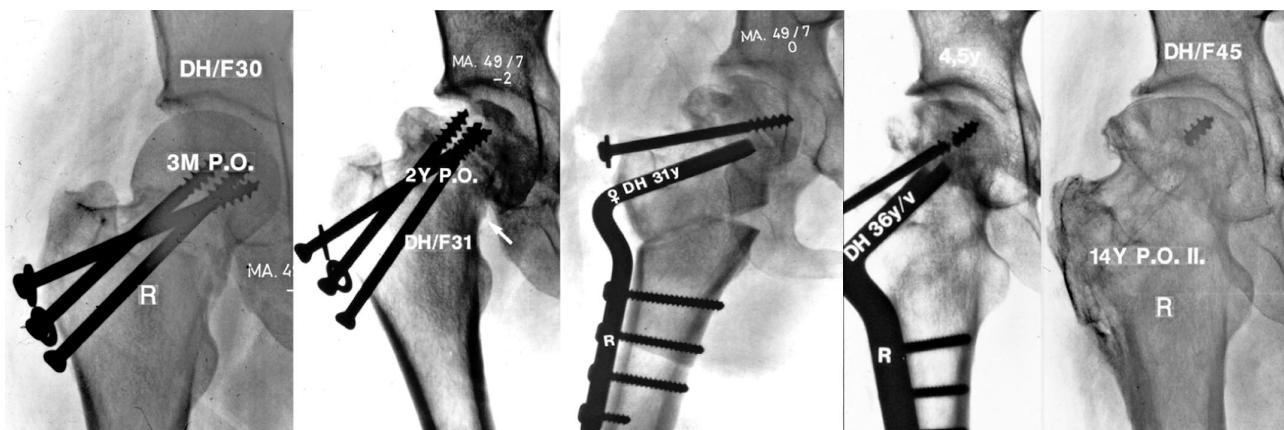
a: Female, 30 years. Three months after screw fixation of a displaced femoral neck fracture. Healed fracture. The patient refused further controls. b: Two years after the primary fracture the patient was readmitted after a fall. She now seems to have a pathological fracture in the necrotic femoral head rather than a nonunion of the former fracture. c: Postoperative x-ray: open reduction of the fracture was performed. The fracture was stabilized only by a screw. Valgisation osteotomy. The blade of the plate did not cross the fracture line in order to avoid additional violation of the already deformed femoral head fragment. d: Healed osteotomy and fracture, 4.5 years postoperative. e: Fourteen years after the osteotomy. There is little trochanter pain, the patient walks one hour without any support. There is no limp, a satisfying ROM and a HHS of 81.
